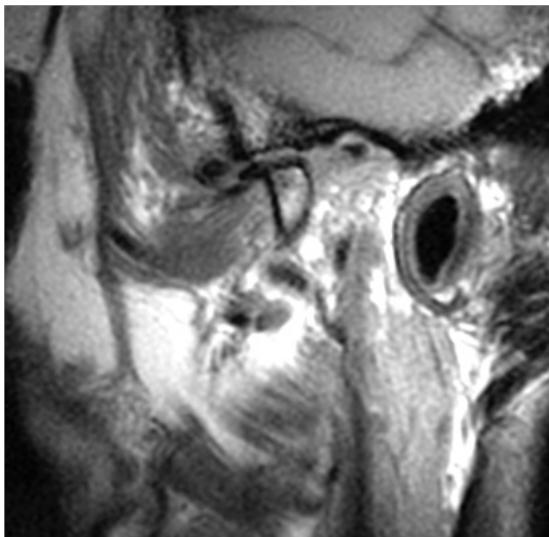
MRI TMJ left open mouth. Absence of disc reduction.
